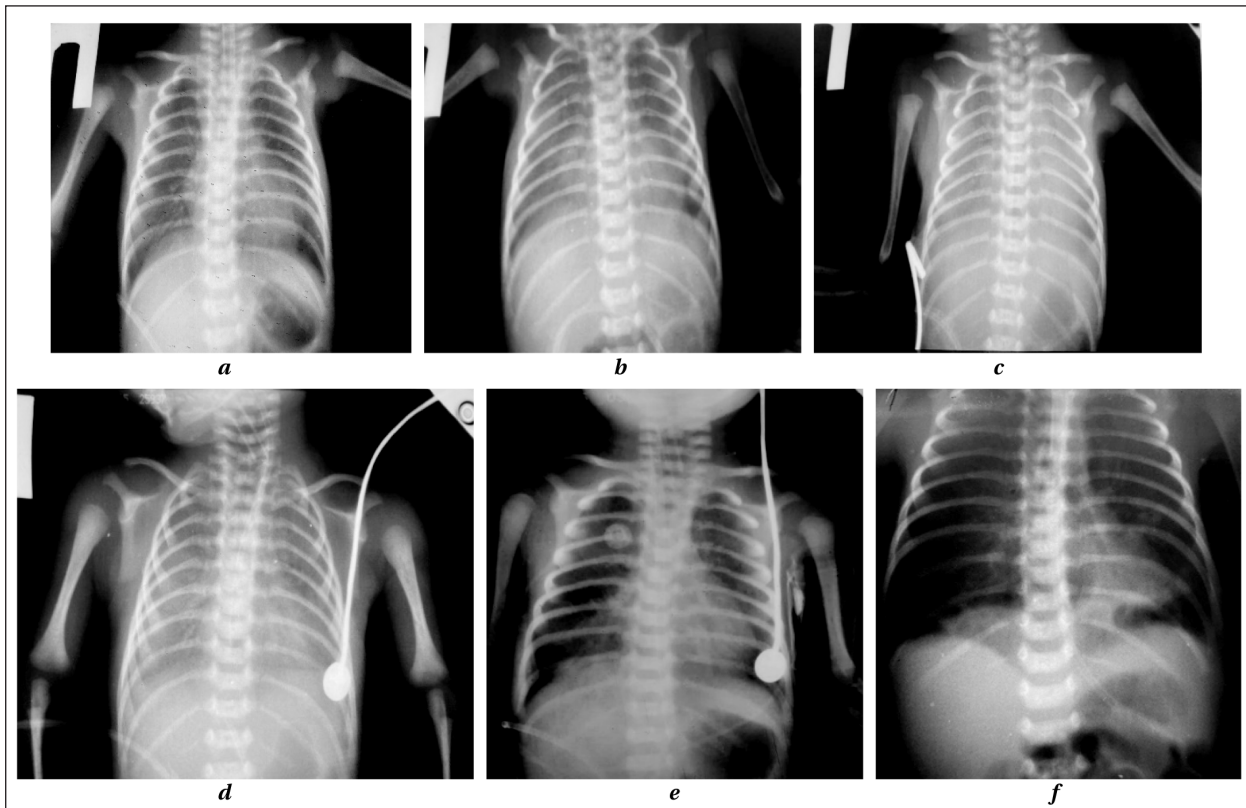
Chest radiography during the study stages.
